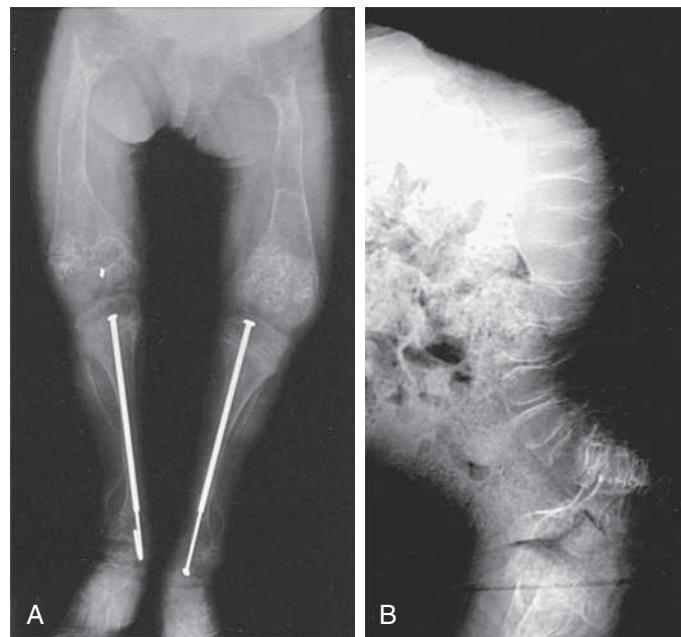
Typical features of type III osteogenesis imperfecta radiographs in a 6-yr-old child. A, Lower long bones are osteoporotic, with metaphyseal flaring, “popcorn” formation at growth plates, and placement of intramedullary rods. B, Vertebral bodies are compressed and osteoporotic.
